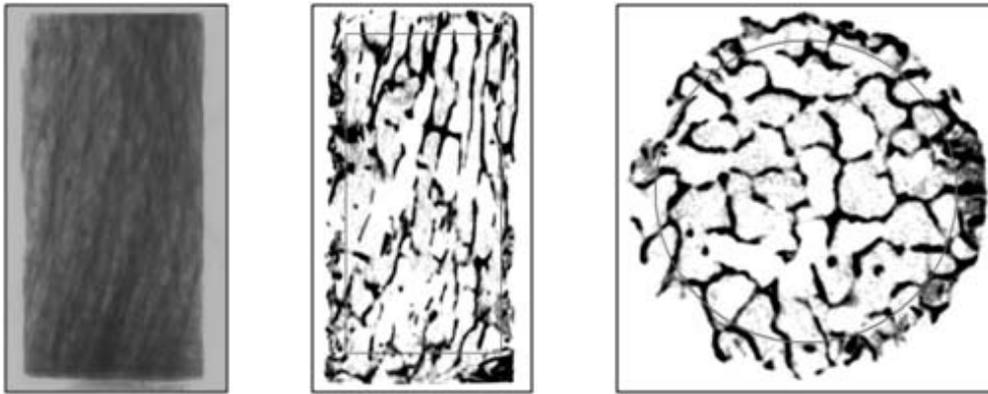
Two-dimensional micro-images of the bone sample (Lt: X-ray transmission image, Middle: sagittal image and Rt: 2D cross-section image). The specific region of interest is defined square and circle.
